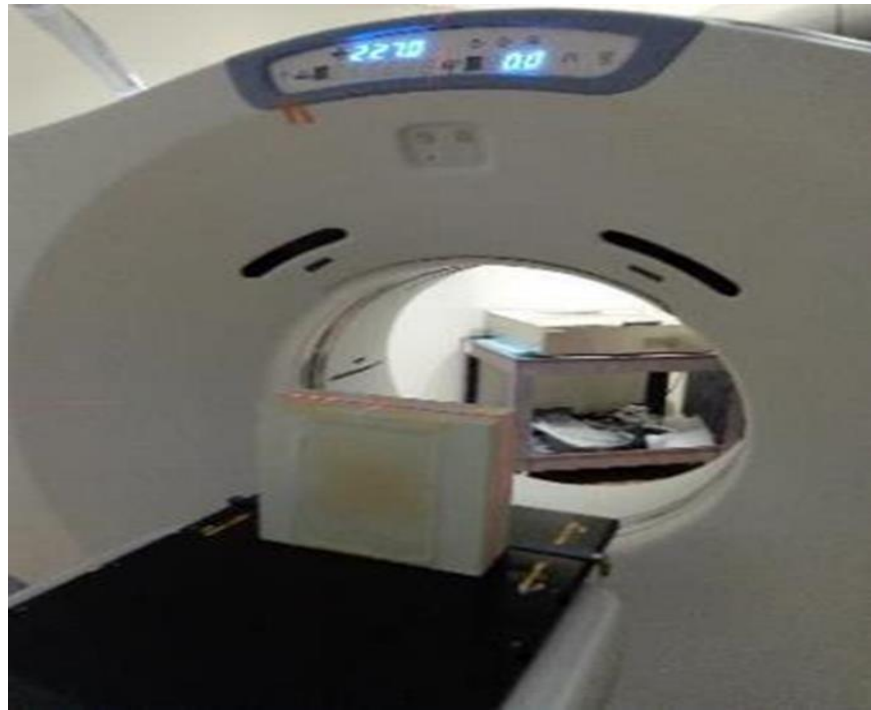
Flat gel attached to solid water and scanned with diagnostic CT
